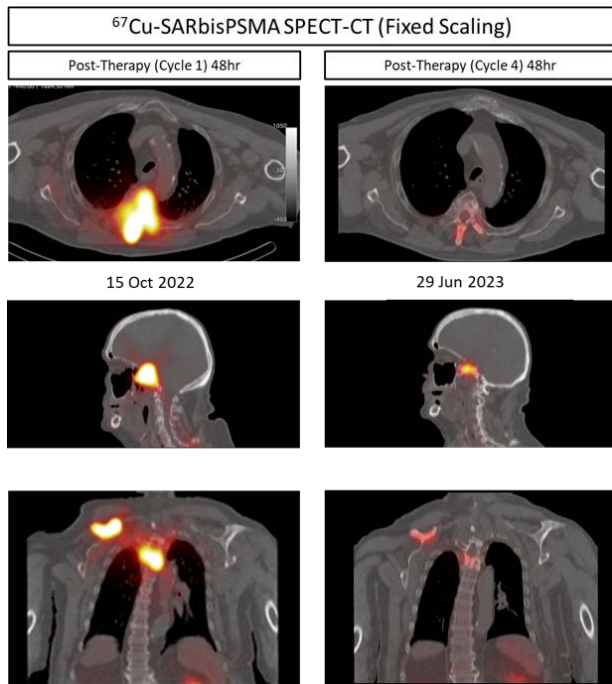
SPECT/CT imaging at 48 hrs following cycle 1 (Oct 2022) and cycle 4 (Jun 2023) of 4GBq ⁶⁷Cu-SAR-bisPSMA.
